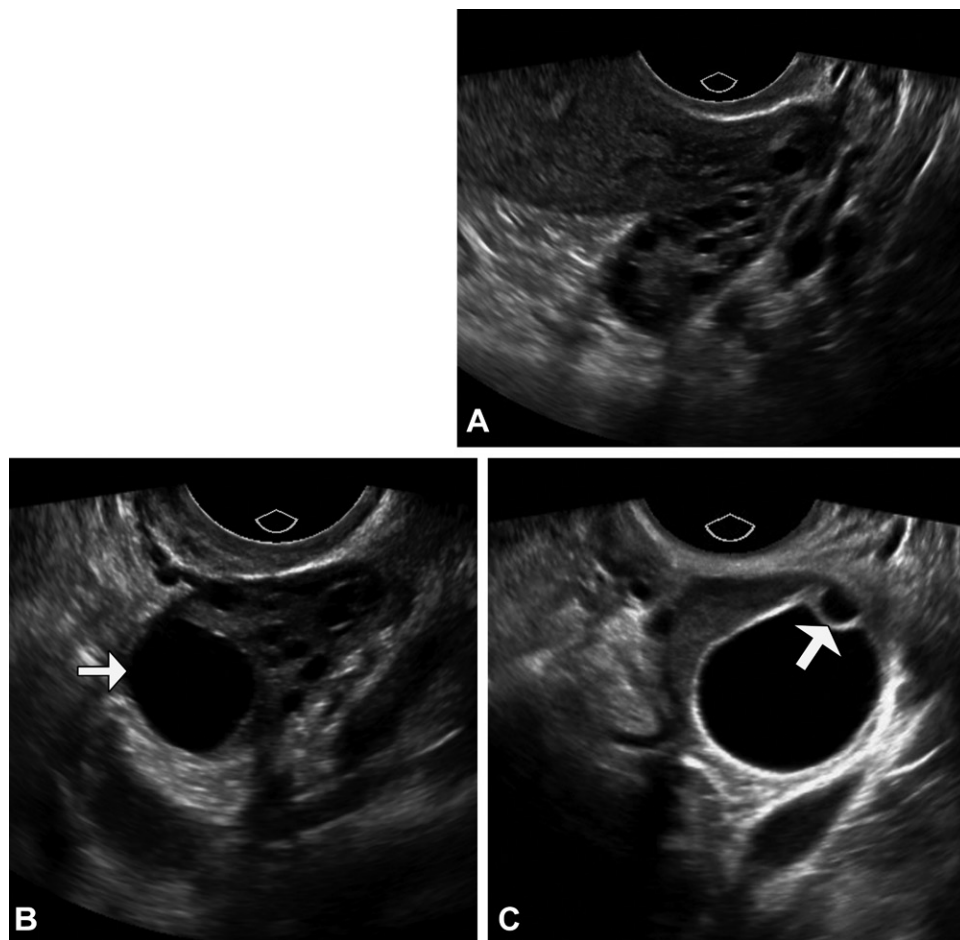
Normal gray-scale sonographic appearance of ovarian follicles in a premenopausal patient. (A) In the early follicular phase, there are multiple small anechoic follicles. (B) In the mid follicular phase, there is a 1.7-cm dominant anechoic follicle (arrow). (C) In the preovulatory phase, the dominant follicle may develop a cumulus oophorus (arrow).
